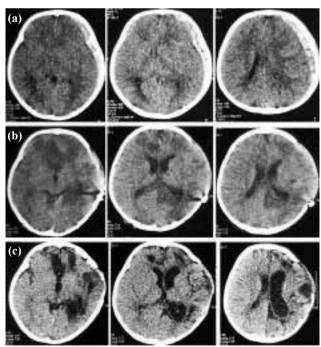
Preoperative (a), 24-hour (b) and 10-day (c) CT scans obtained in a 4-year-old female with TBI undergoing early unilateral decompressive craniectomy as the primary therapy.
